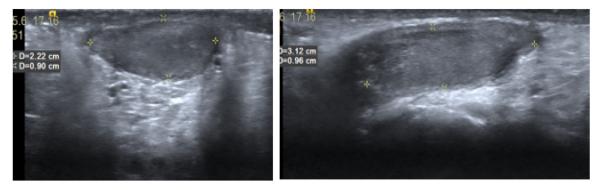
Longitudinal Ultrasound images of both testes after orchidopexy, show small, heterogeneous and atrophic testes.
